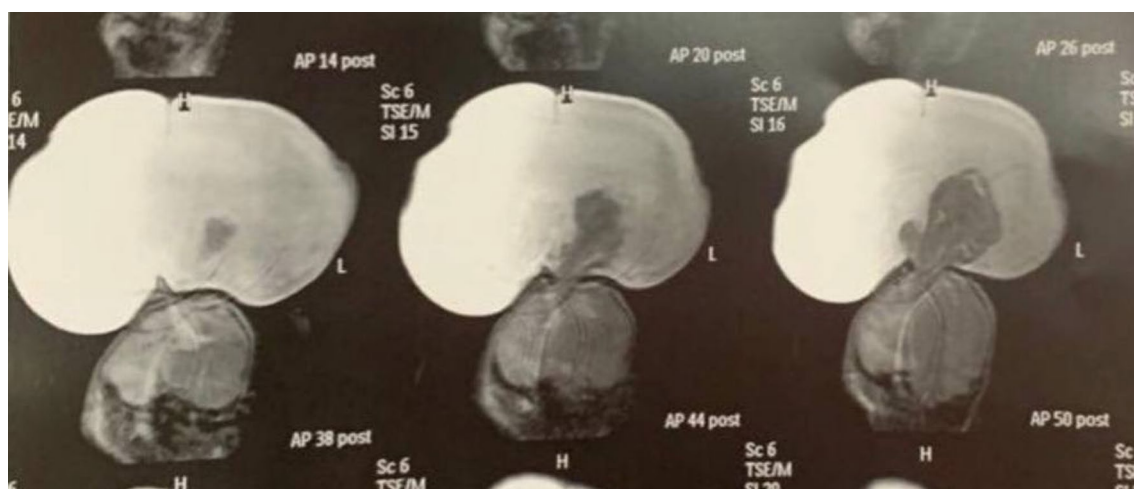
MRI T2 (coronal view) of parietal encephalocele our case study
